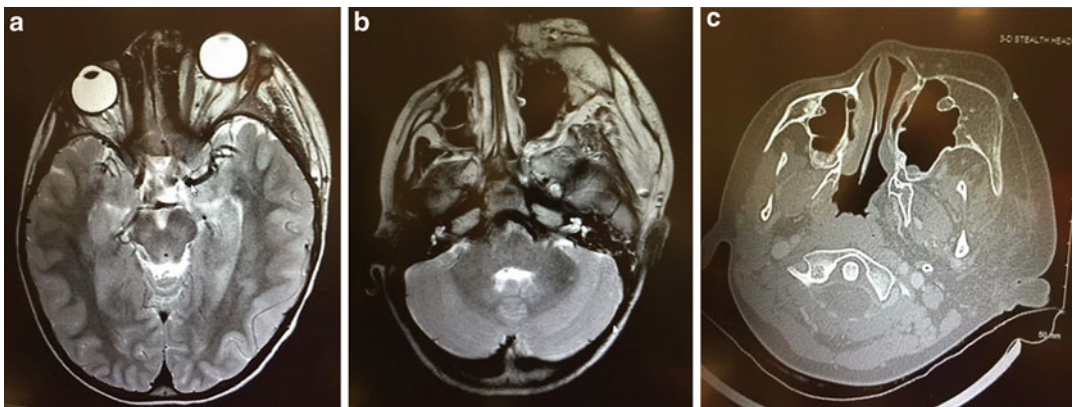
(a–c) MRI of the brain and orbits showed extensive fatty tissue infiltration in the left side of the face with involvement of the orbit, infraorbital fissure, and inferior portion of the left cavernous sinus. There was proptosis
